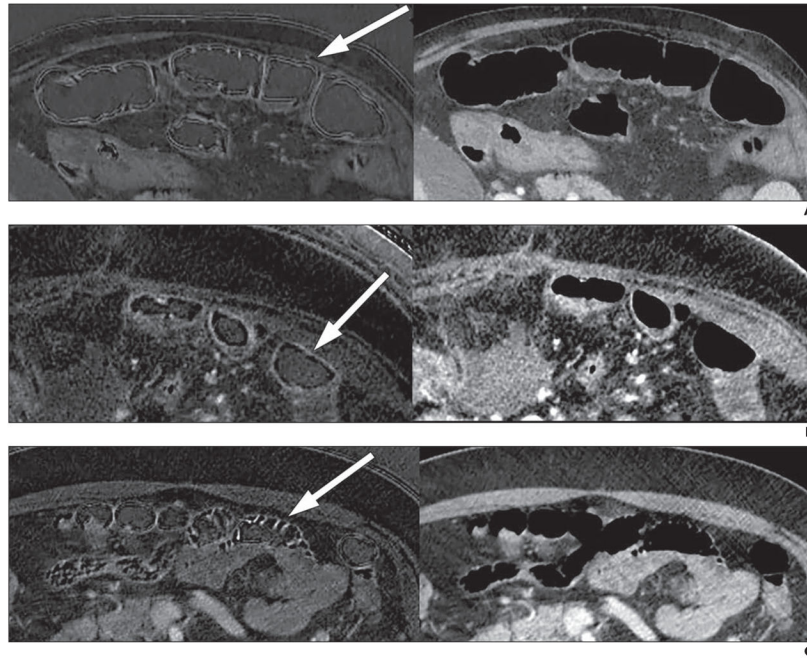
Interface artifact on dual-energy CT iodine-density images and 65-keV images
